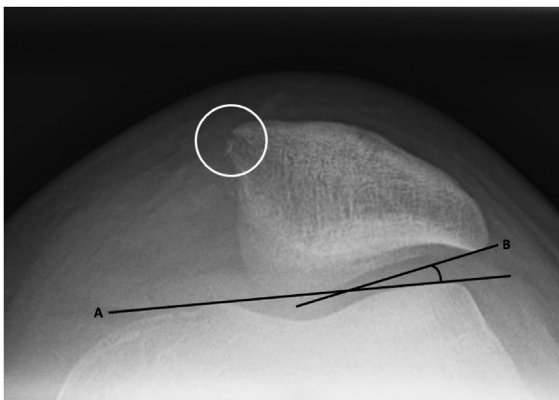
Axial radiograph depicting a medial rim avulsion fracture (white circle). The lateral patellofemoral angle is the angle between lines A and B.
